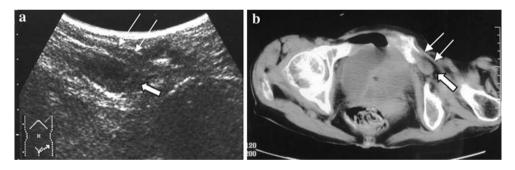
Ultrasonogram and CT image of the Case 3. a Re-examination with ultrasound showed the herniated segment of the small bowel (*broad arrow*) beneath the pectineus muscle (*arrows*). b CT
